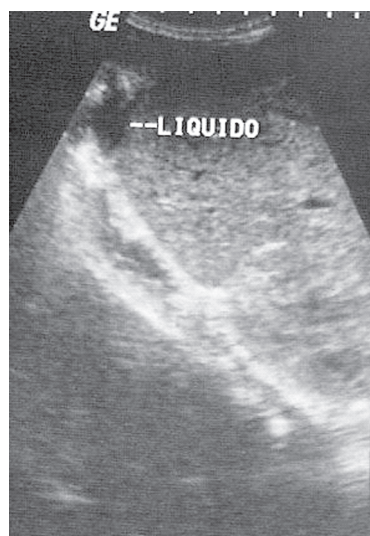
Ultrasonography – small quantity of fluid at the anterior wall of the liver.
